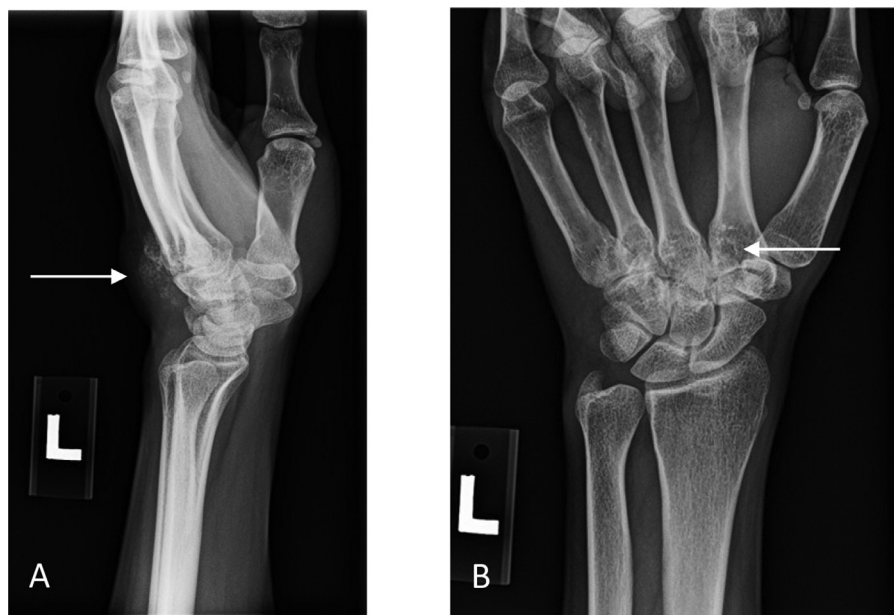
(A) – Lateral radiograph of the left hand showing a focal lesion (white arrow) at the dorsal aspect of carpometacarpal level with mineralizations in it. (B) PA view of the left wrist displaying lucent lesions (white arrow) in the second to fourth metacarpals and hamate. The calcified mass is difficult to see on this radiograph.
